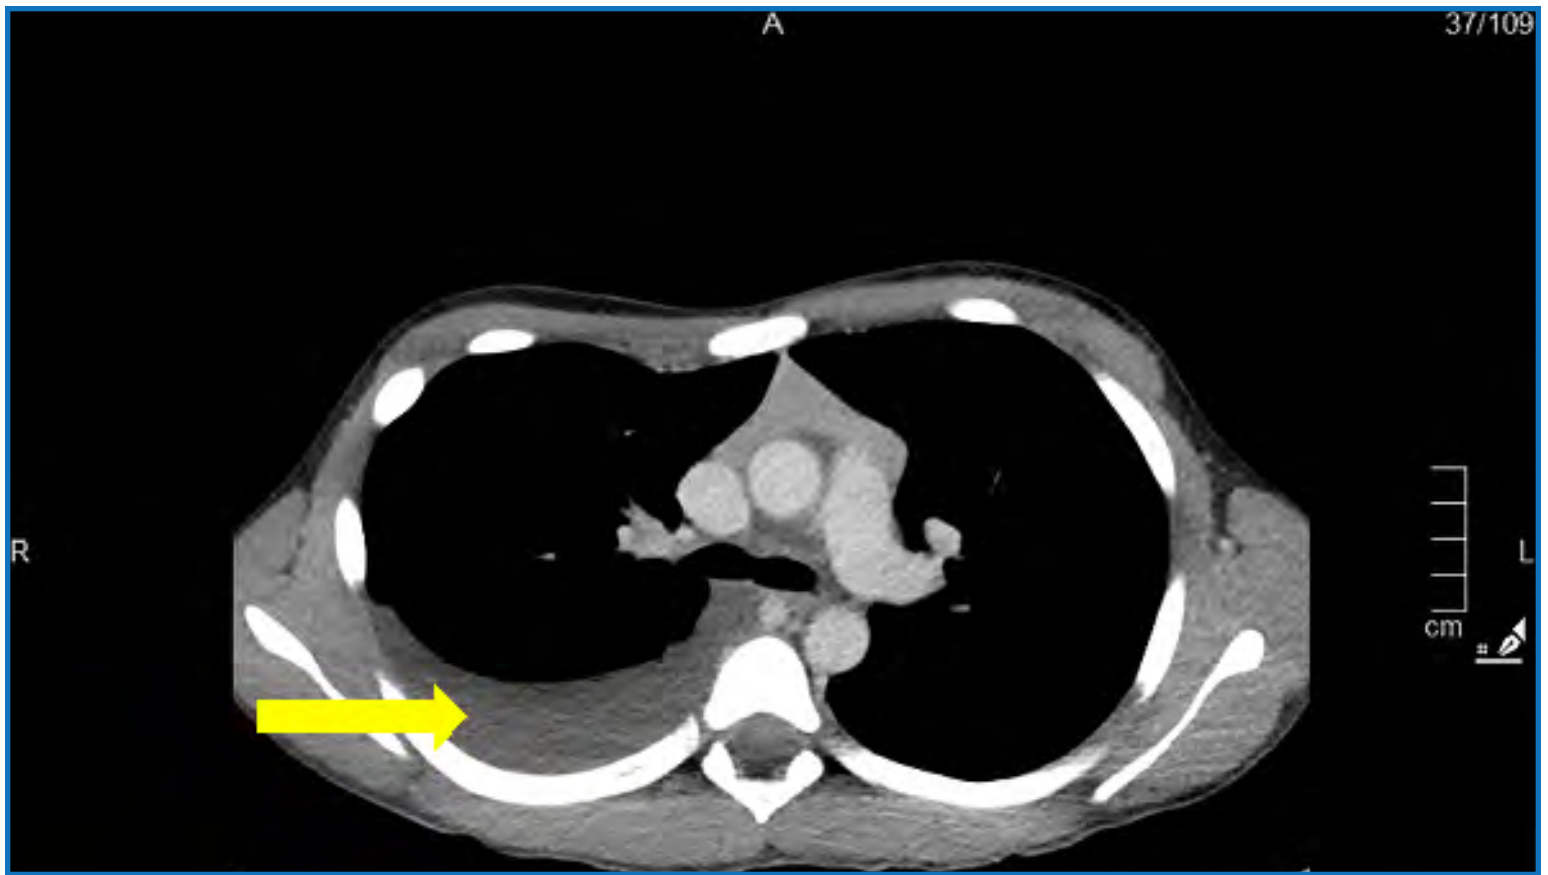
CT imaging significant for right-sided pleural effusion.
